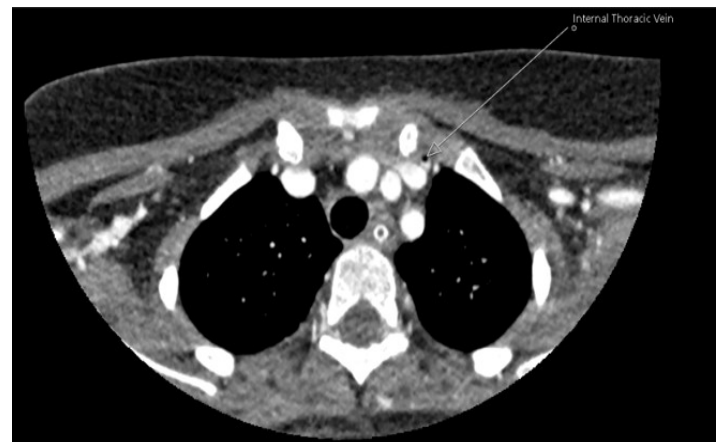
Parenchymal window images of enhanced cranial CT. Air density in the left internal thoracic vein (white arrow).
